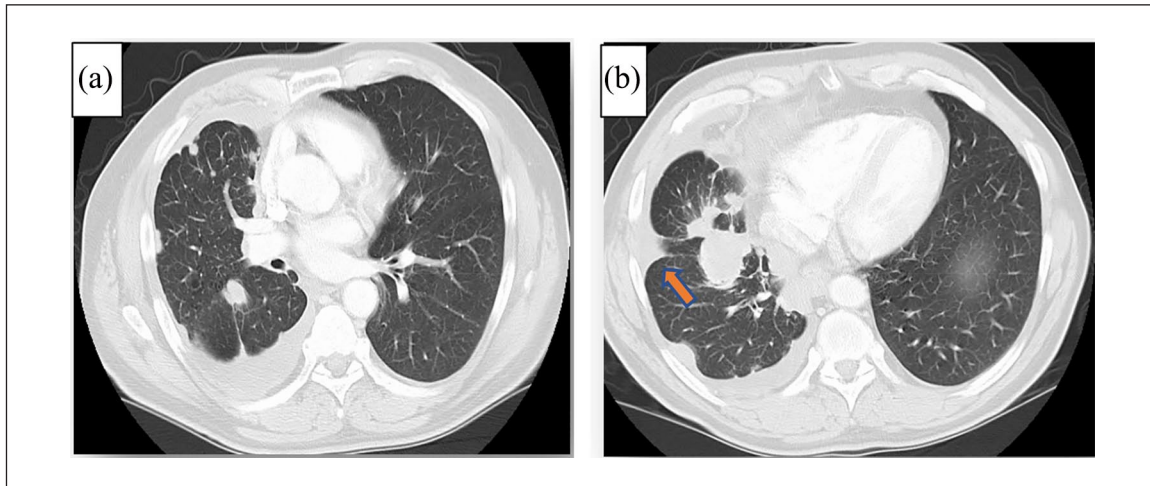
A CT chest of the patient for initial evaluation. a) and b) both cuts show a right hemithorax mass involving the pleura (red arrow in b).
